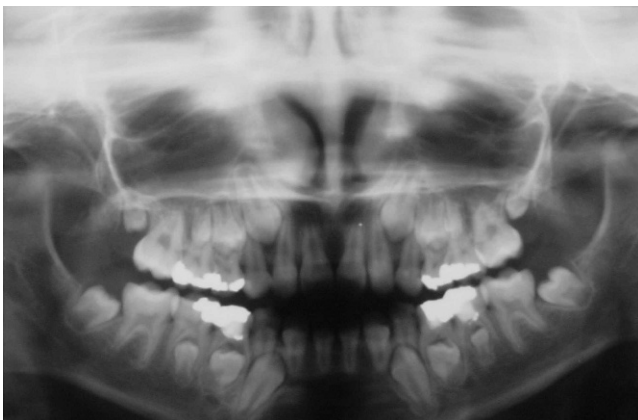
Panoramic radiograph of a 2-year-old patient at diagnosis who was submitted to chemotherapy and 1,800 cGy irradiation. Note microdontia of the lower left premolars and second permanent molar.
